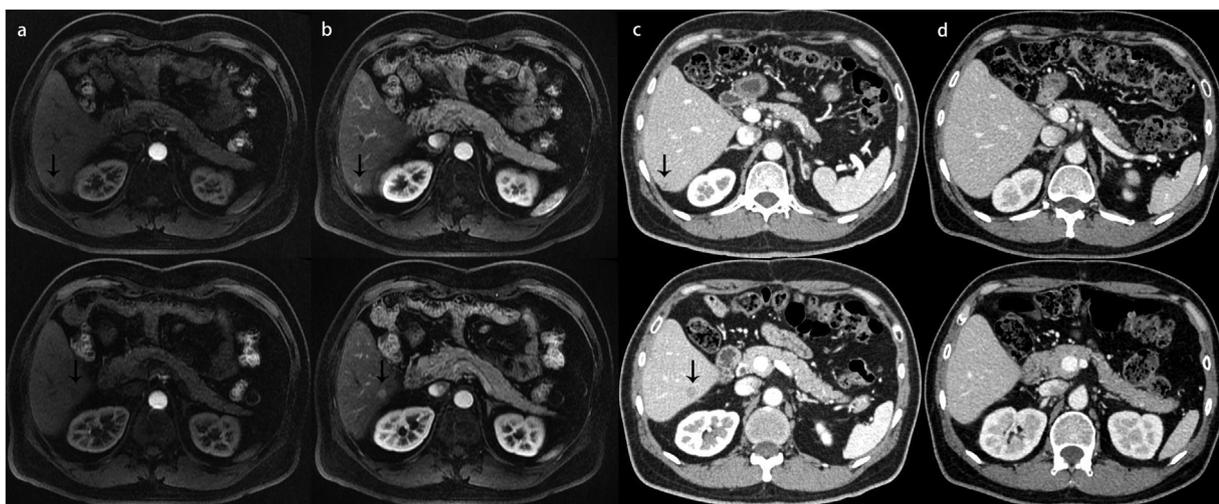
a. Two tumors (black arrow) shown in arterial phase of MRI T1 sequence; b. two tumors (black arrow) shown in venous phase of MRI T1 sequence; c. contrast enhanced CT showed two tumors (black arrow) in the S6 of liver before the combination therapy; d. contrast enhanced CT showed tumor disappearance after 6 cycles of combination therapy. MRI, magnetic resonance imaging; CT, computerized tomography.
